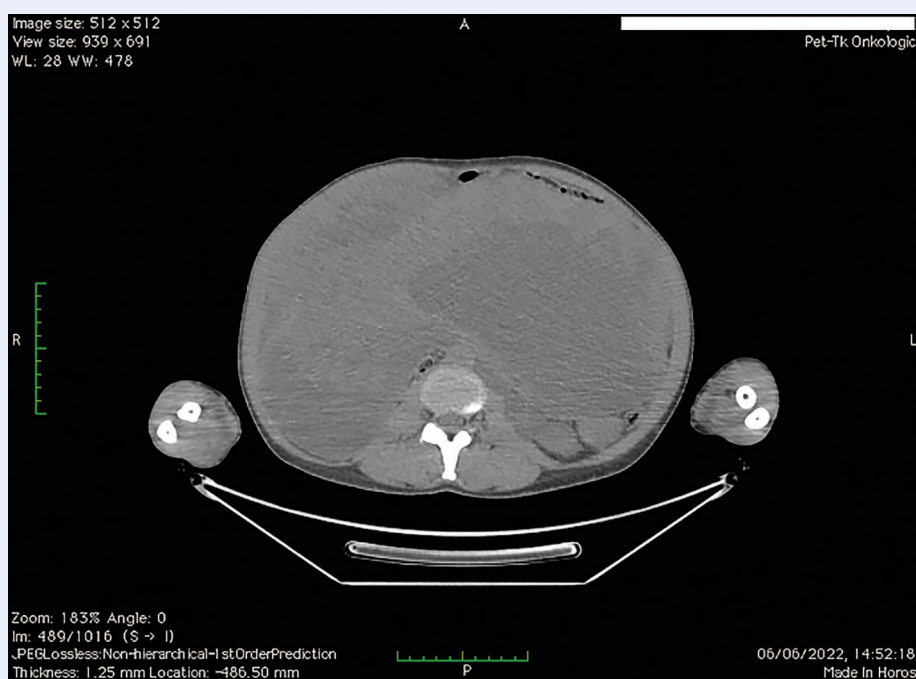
A computed tomography scan revealing a gigantic tumor in the abdominal cavity
